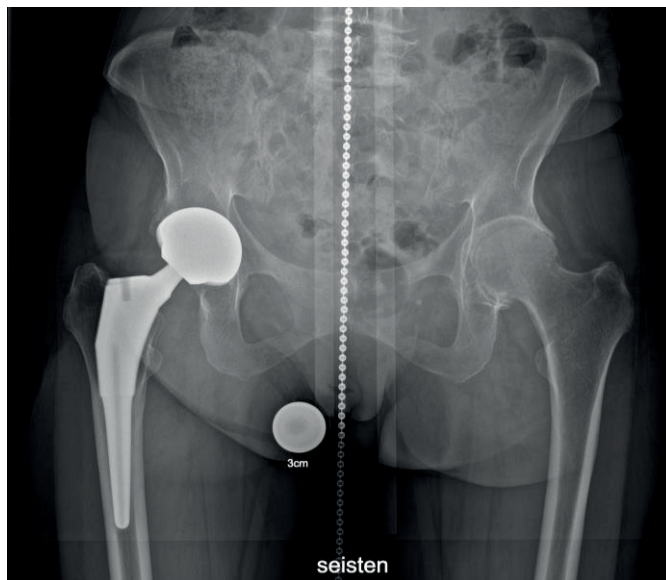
Total hip replacement in the right hip and normal femur and acetabulum in the left hip in an anterior X-ray image of a female patient.
